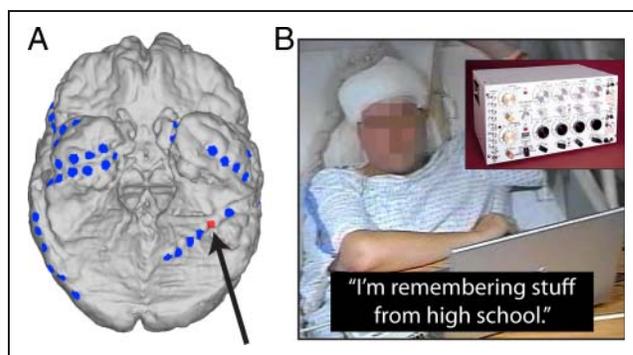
Stimulation induces retrieval of HS memories. (A) A three-dimensional reconstruction of this patient’s brain surface generated from preoperative magnetic resonance images. The position of each recording electrode is plotted as a colored dot on a ventral view of the patient’s brain surface (dots not to scale). (B) Anonymized image of the patient during ECoG monitoring. When we stimulated one electrode in the patient’s left ventral temporal lobe, the patient reliably reported that he recalled memories related to his HS. The electrode where stimulation elicited HS memories is colored red and marked with an arrow in A. This site was labeled Electrode 17 in our recording montage.
